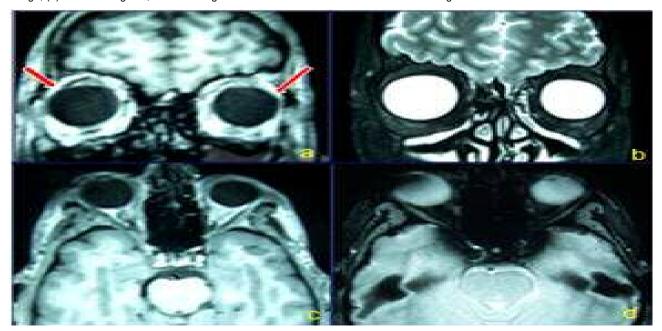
MRI (a) Coronal T1-weighted, non-contrast image (b) Coronal T2-weighted, contrast image; (c) Axial T1-weighted, non-contrast image; (d) Axial T2-weighted, contrast image. The arrows showed absence of both lacrimal glands.
